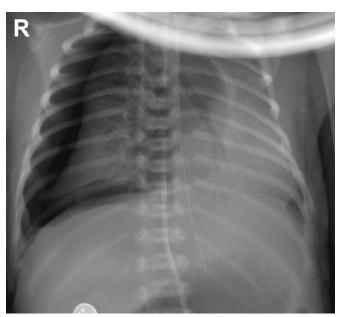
Chest Radiography - right-sided pneumothorax.
